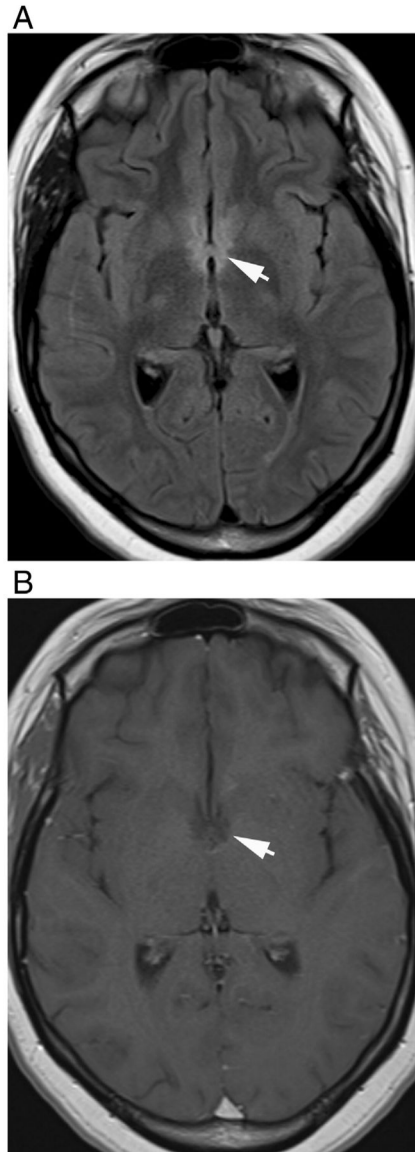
Periependymal linear enhancement in two different patients with seropositive NMO during first acute TM attack. (A) Axial FLAIR and (B) T1-weighted contrast-enhanced images of a 21-year-old female show periependymal linear hyperintensity and linear enhancement along the frontal horns of lateral ventricles. (C) Axial FLAIR and (D) T1-weighted contrast-enhanced images of a 35-year-old female demonstrate periependymal linear hyperintensity and linear enhancement around the cerebral aqueduct (arrows).
